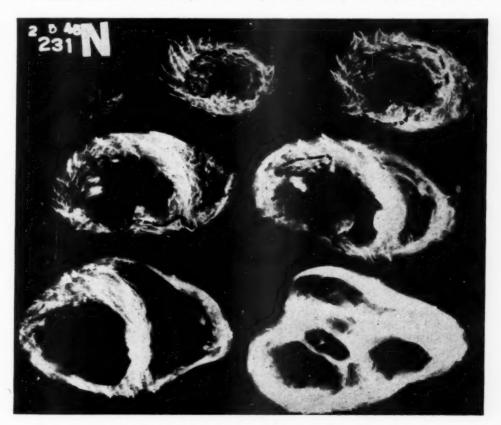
Roentgenogram of the injected heart in Case 82, showing position of old, healed anterolateral, septal, and posterior infarcts.
